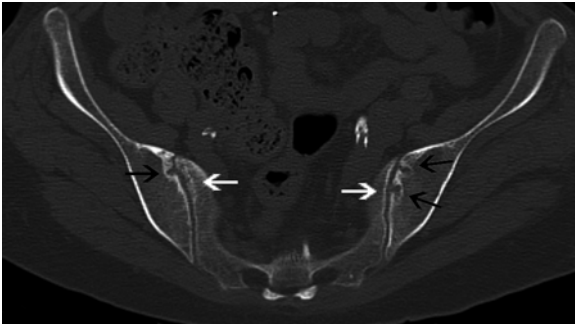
Axial CT of the pelvis demonstrates bony erosions of the bilateral iliac wings (*black arrows*) with sparing of the sacrum (*white arrows*), consistent with sacroiliitis. Ferguson view of the pelvis (“pelvic outlet radiograph” not shown) will accentuate the sacroiliac joints and may reveal sacroiliitis without the need for CT.
